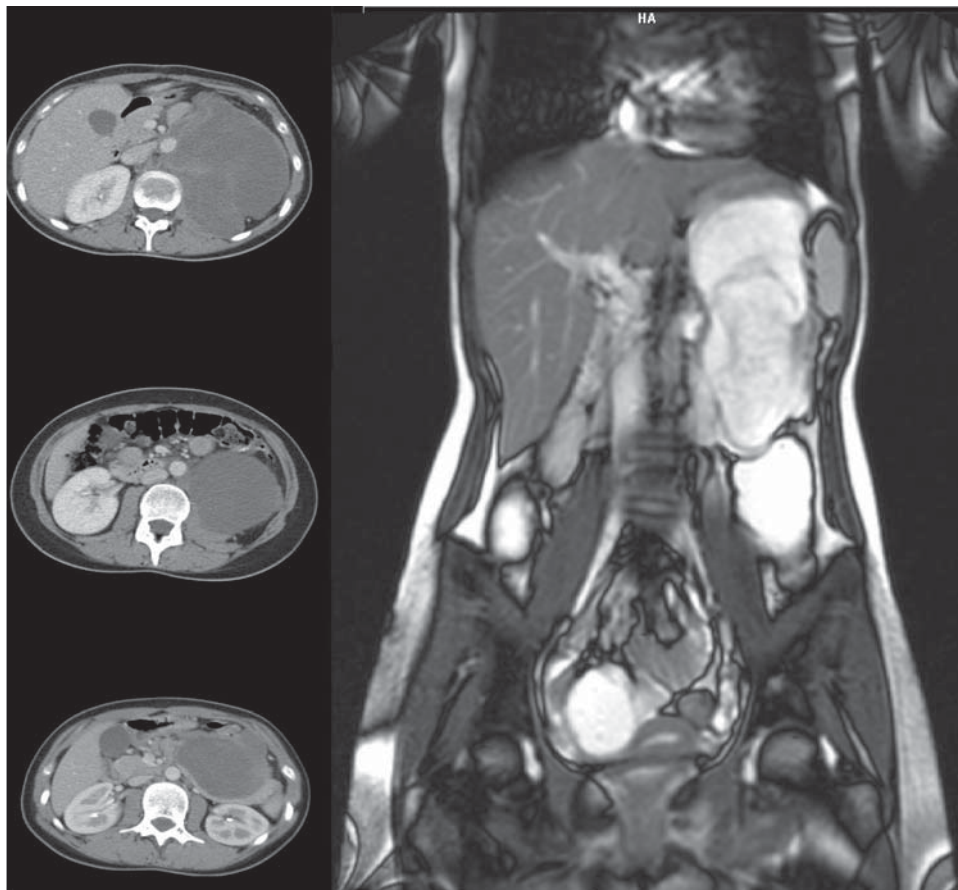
Abdominal computed tomography showing a large soft tissue mass in the left retroperitoneal area associated with the tail of the pancreas infiltrating aorta and branches of the aorta.
